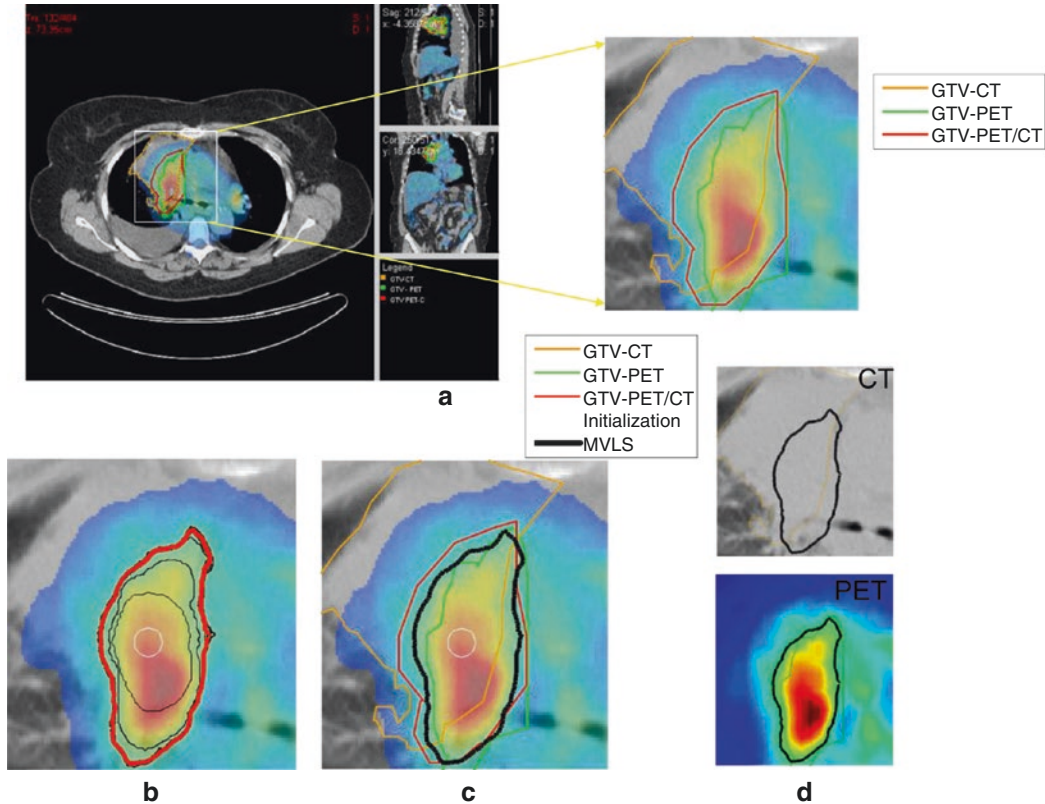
Joint estimation of lung PET/CT target/disease volume. (a) A fused PET/CT displayed in CERR with manual contouring shown of the subject’s right gross tumor volume. The contouring was performed separately for CT (*in orange*), PET (*in green*), and fused PET/CT (*in red*) images. (b) The MVLS algorithm was initialized with a circle (*in white*) of 9.8 mm diameter, an evolved contour in steps of ten iterations (*in black*), and the final
